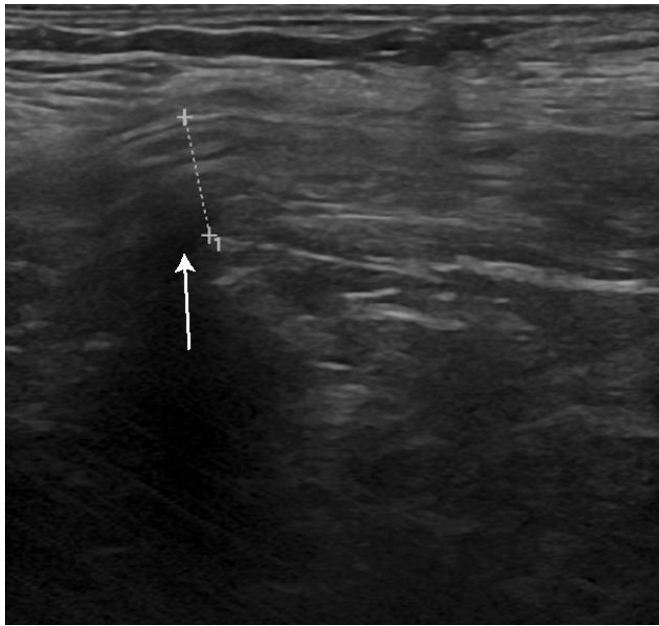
Ultrasound sagittal images of the right inguinal region: inguinal hernia neck (left) represented by the white arrow; intestinal content (red arrows) inside the inguinal canal (right).
